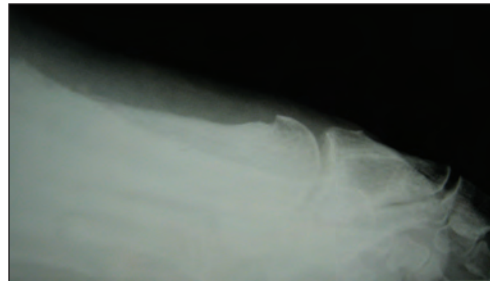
Case 4: Plain Radiograph Showing First Metatarsal Elevatus
